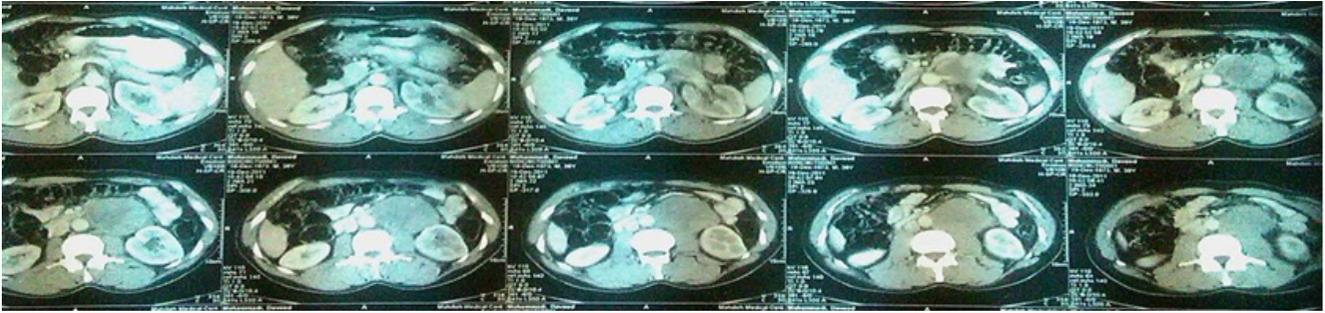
Preoperative computed tomography scan showed the tumor adjacent to the renal pedicle.
